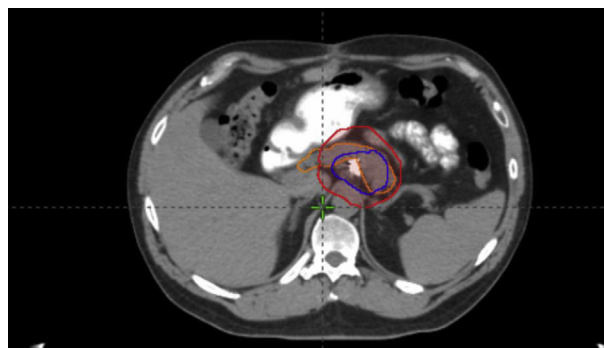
Mapping of the treated lesion based on the patient's preradiation therapy abdominal computed tomography scan. Orange = pancreas; red = planning target volume; blue = gross tumor volume SUV 3.5.
